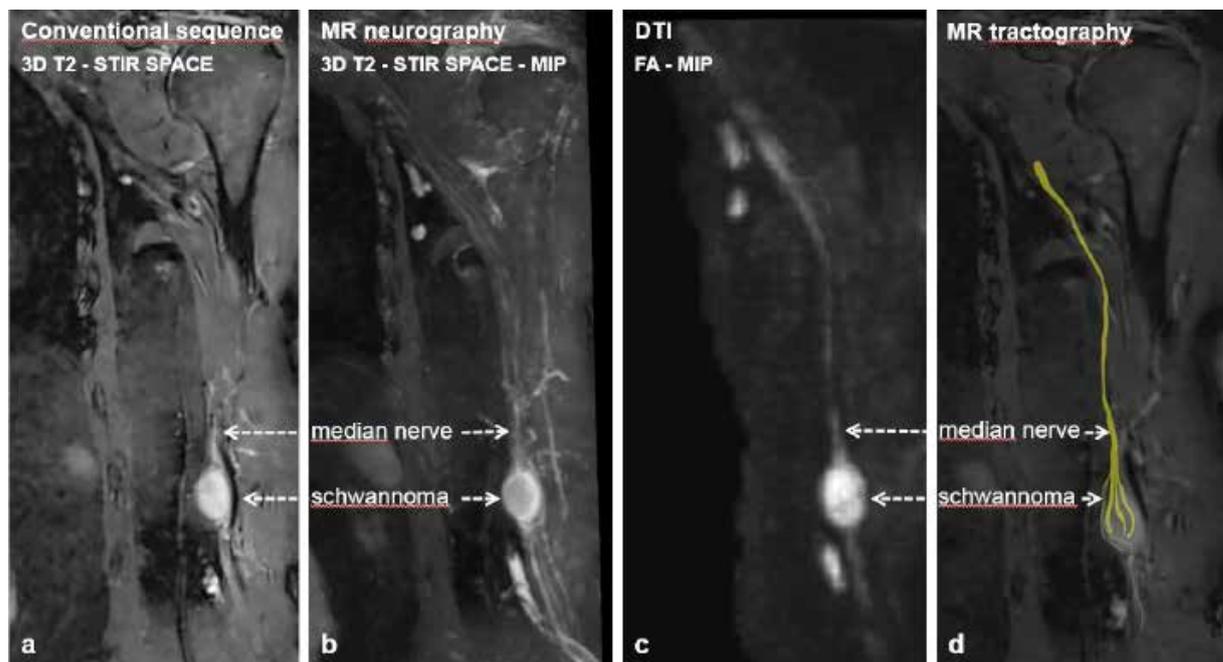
Median nerve schwannoma showed using (a) conventional MRI sequence – 3D T2-STIR SPACE, (b) MRN-3D T2-STIR SPACE-MIP reconstruction, (c) DTI-FA-MIP reconstruction and (d) MRT
